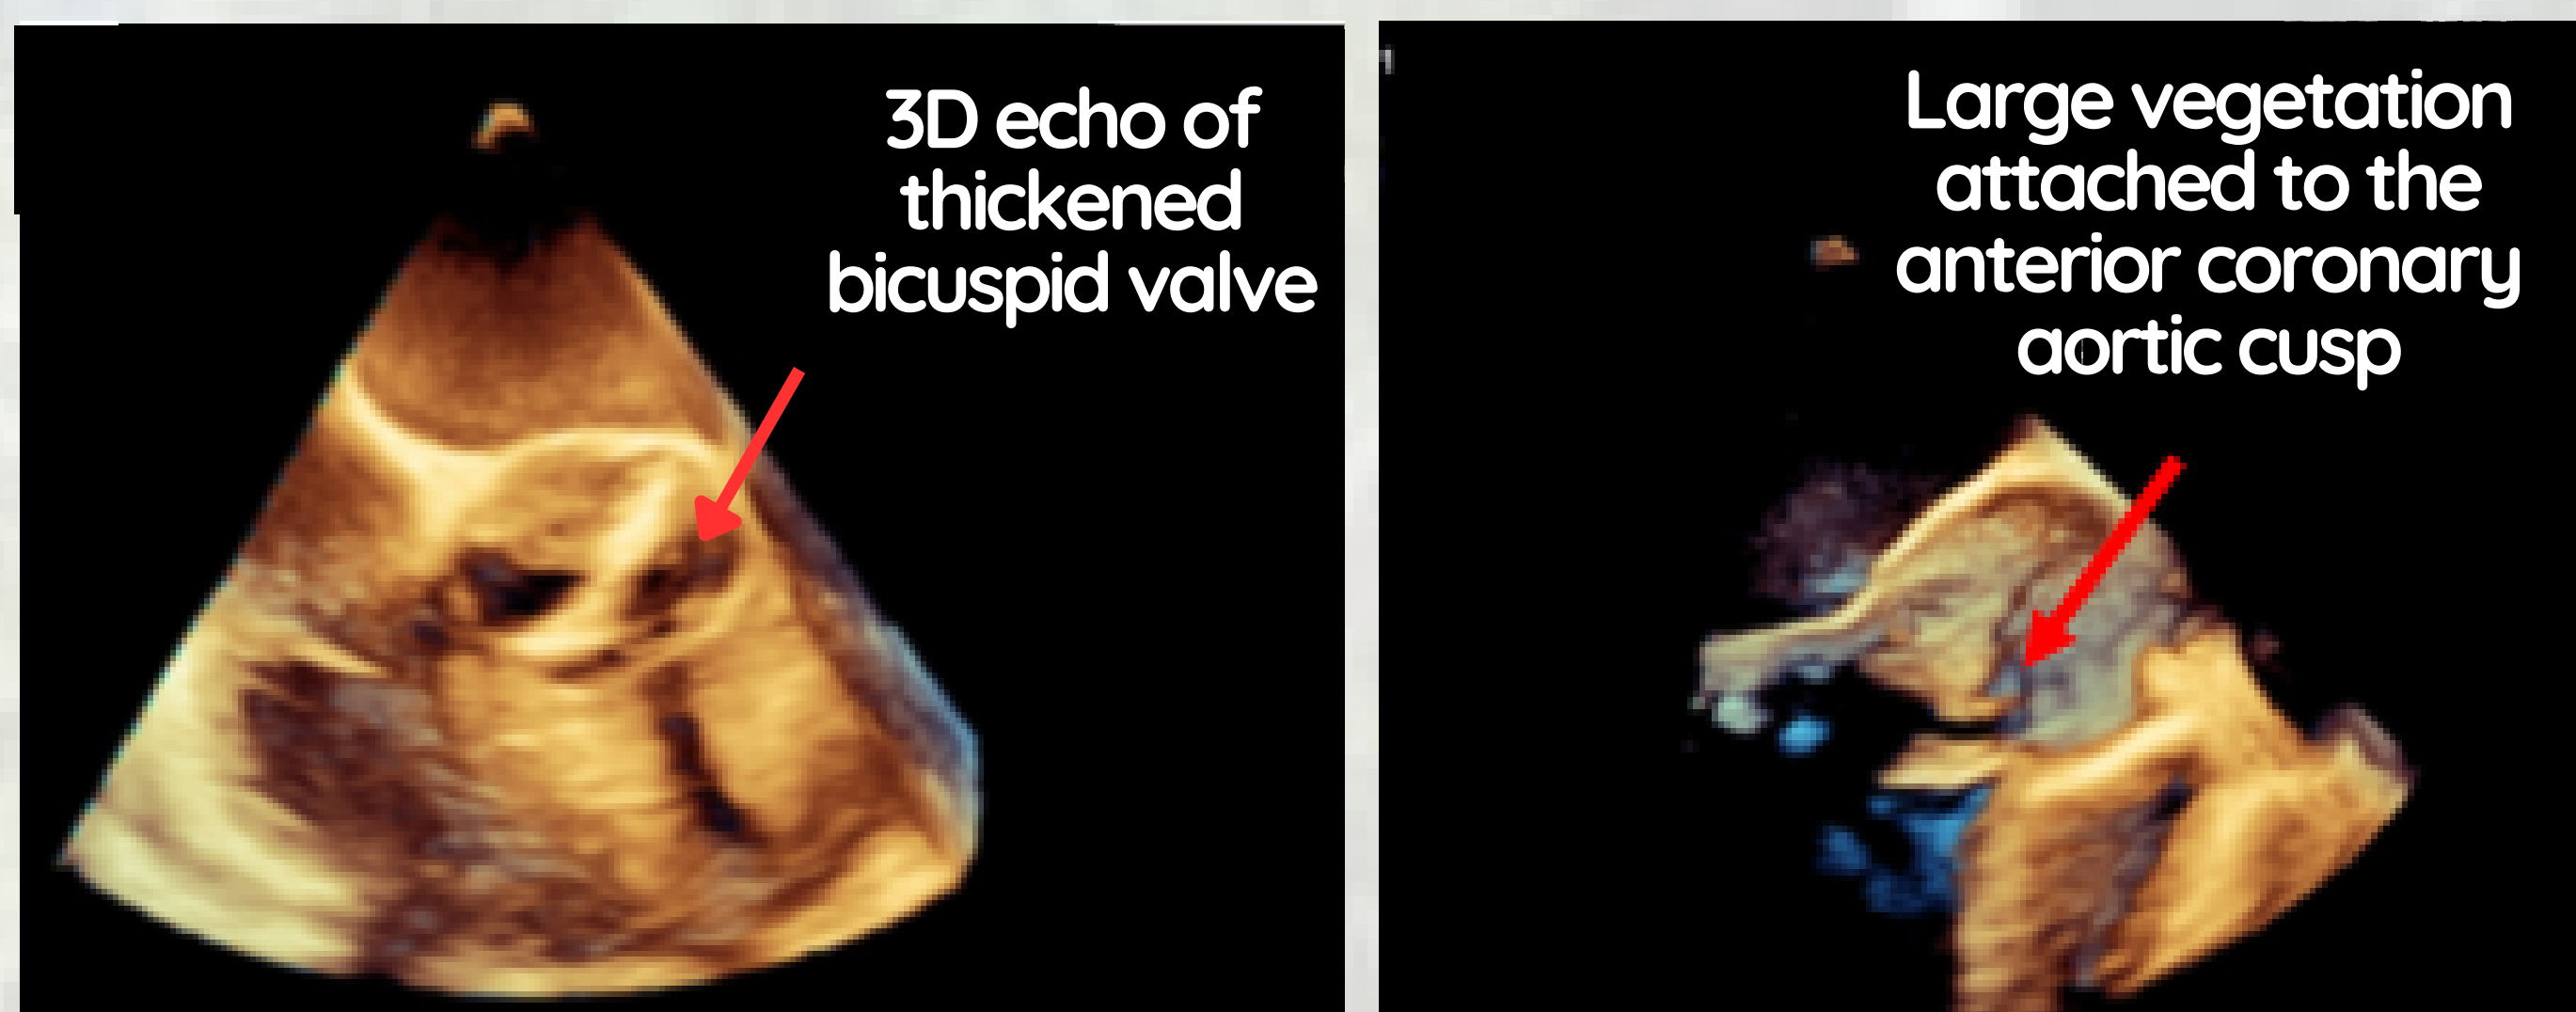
Shows the transesophageal 3D echocardiography of the thickened bicuspid aortic valves (red arrow pointing). 2B Oscillating echogenic densities are seen attached to both cusps. The red arrow pointing to the bicuspid aortic valves with vegetation measuring 56.9 x 11.9mm which results to a poor coaptation
